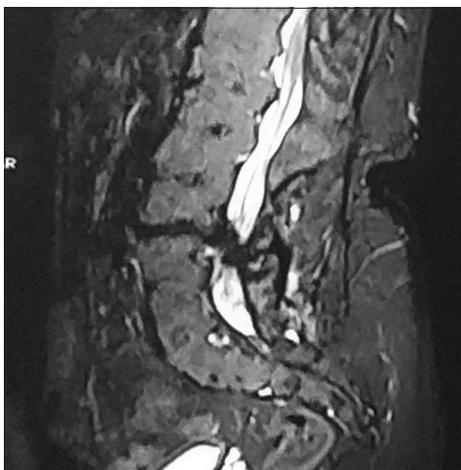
MRI scan of lumbosacral spine sagittal view: lumbar canal stenosis is seen at L3-4 level due to diffuse disc bulge, facet arthropathy, and osseous malformation of L3 and L4 vertebral bodies.
